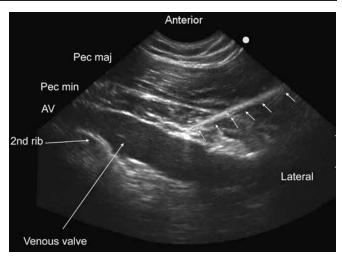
In-plane technique: Ultrasound image with a curvilinear probe. The arrows point to needle. The needle tip has just made contact with anterior wall of vein (Pec maj: Pectoralis major muscle; Pec min: Pectoralis minor muscle; AV: Axillary vein). A venous valve is seen just lateral to 2nd rib. Guide wire tip may monitored across the venous valves when they are visible or resistance to guide wire advance is encountered
